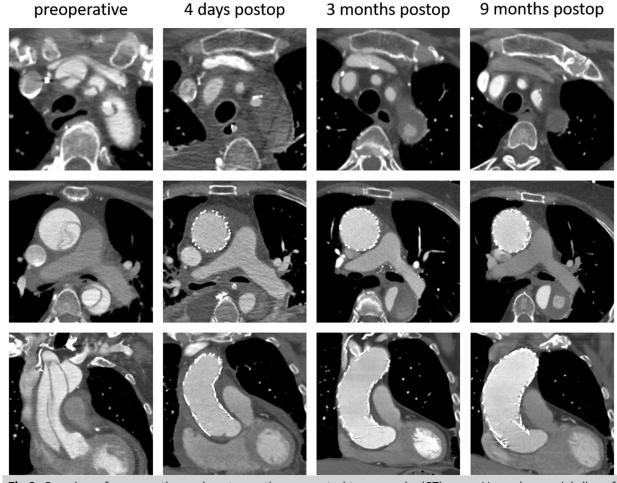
Overview of preoperative and postoperative computed tomography (CT) scans. Upper layer axial slice of brachiocephalic arteries. Middle layer axial slice of ascending and descending aorta at level of pulmonary artery bifurcation. Lower layer coronal slice of ascending aorta. (Left) The total aorta diameter (true and false lumen) measured 43 mm. The intimal entry was located approximately 6 cm distal to the coronary ostia and 1 cm proximal to the brachiocephalic trunk (BCT).
